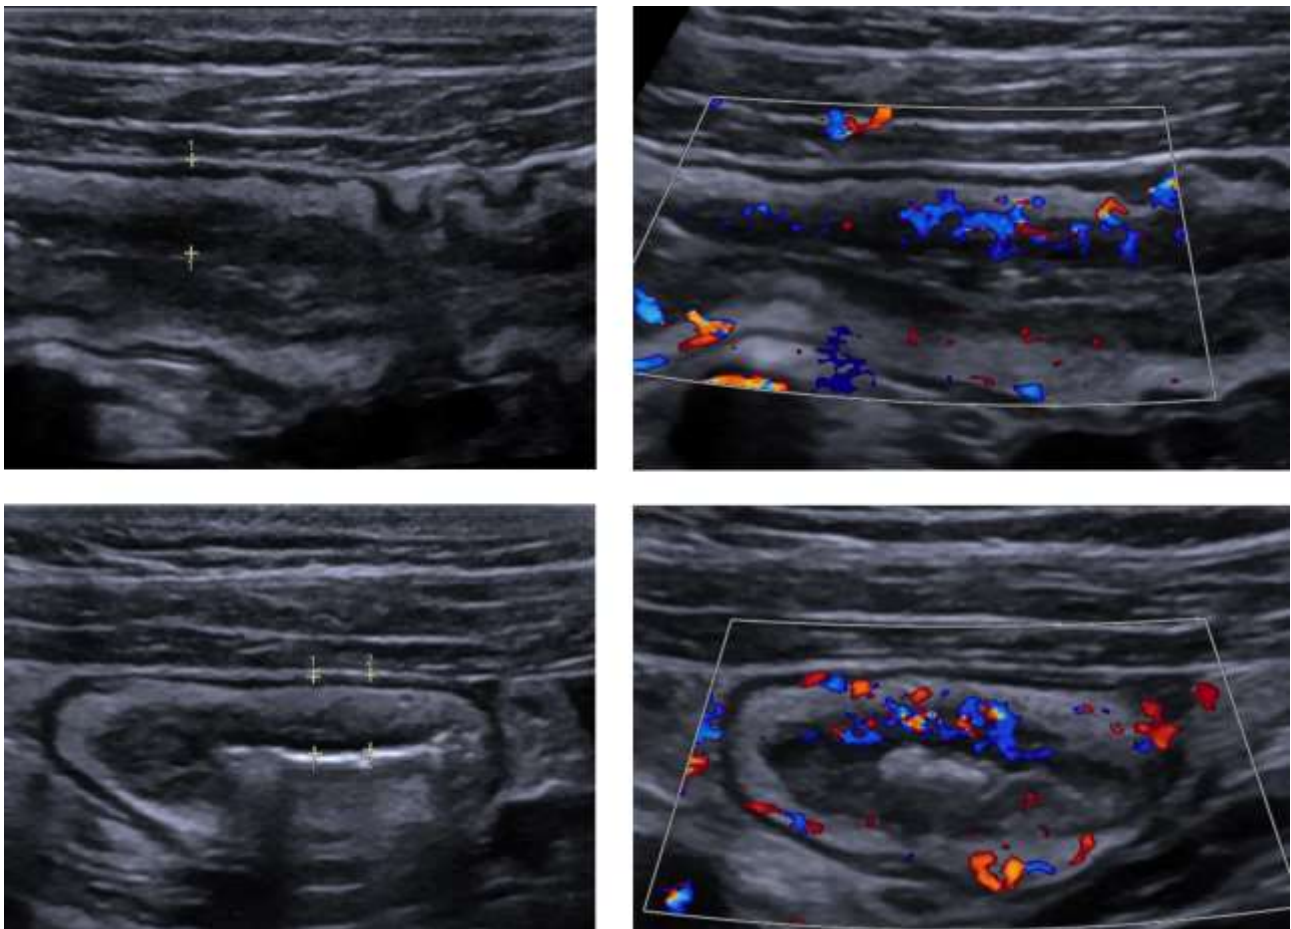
Terminal ileum in a 26 years female with suspected CD. IUS with longitudinal and cross-sectional images of the terminal ileum, showing intestinal wall thickening (5mm) with preserved wall layers – color Doppler on the right.
